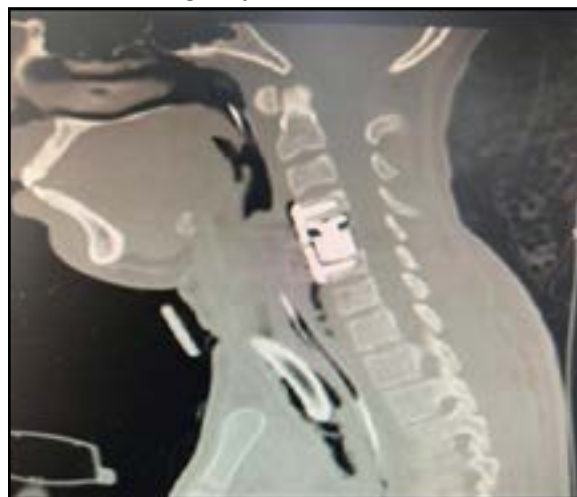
Preoperative coronal CT scan showing neck swelling, a prevertebral abscess and air bubbles at the prevertebral space.
